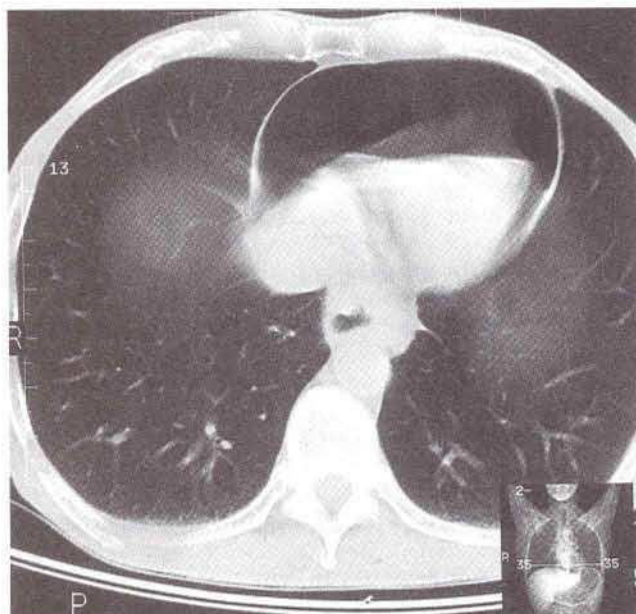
CT scan showing pneumopericardium before pericardial drain insertion.
